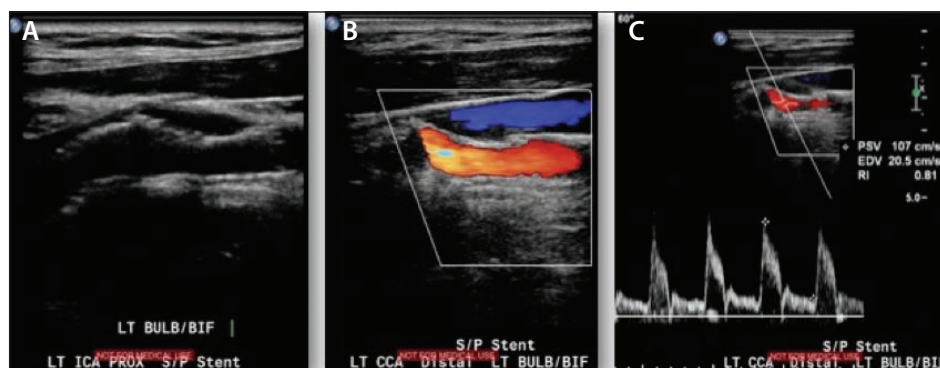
Duplex ultrasound 1 year after TCAR demonstrating a patent left carotid stent on B-mode (A), color flow (B), and Doppler (C).
